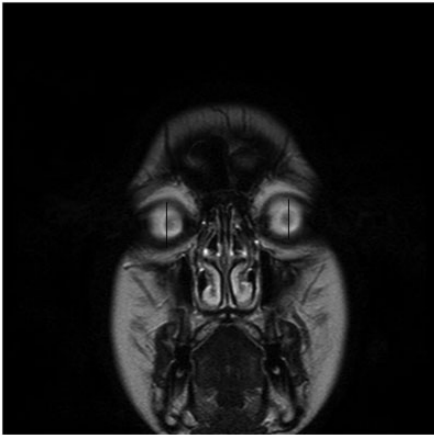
An axial fat-suppressed T2-weighted image shows increased signal intensity in the middle ear (long arrow) and petrous apex (short arrow) when compared with the normal contralateral side. Hyperintensity is also seen in the lumen of the right sigmoid sinus, which is consistent with thrombus formation (white arrowhead). Medial deviation of the right globe is present (lines), suggesting ipsilateral abducens nerve palsy.
